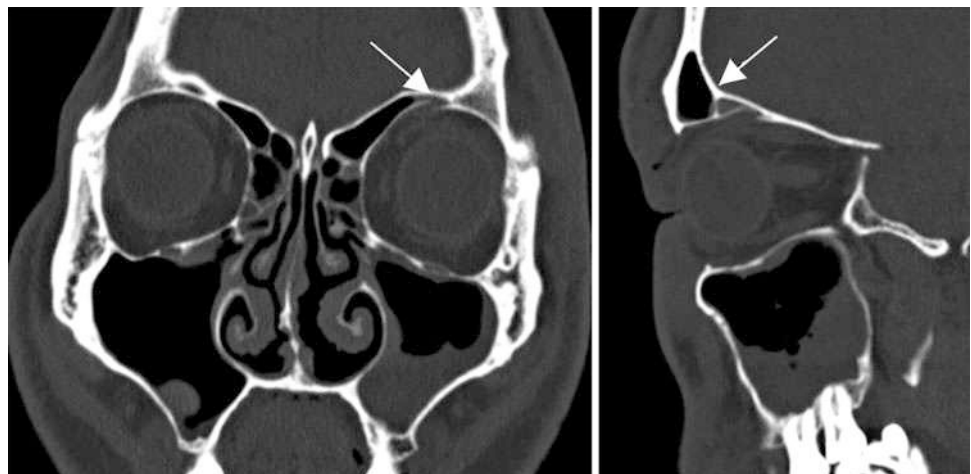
CT scan coronal and sagittal bone windows: Left orbital roof blow-out fracture with minimal prolapse into the frontal sinus
